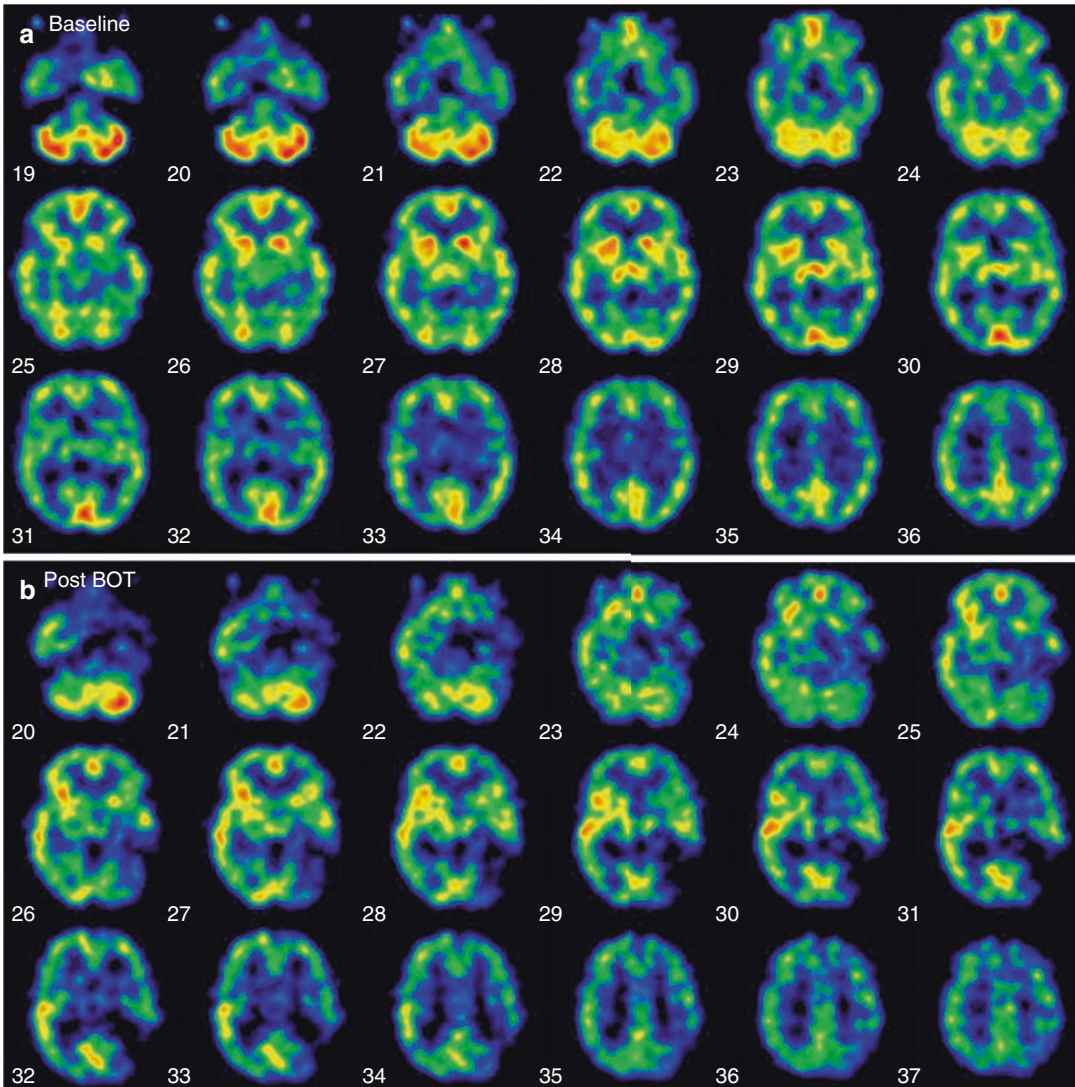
(a) Pre-balloon occlusion baseline study: patient is a 55-year-old female with a skull base meningioma. The patient was injected with radiopharmaceutical (44.5 mCi of ^{99m}Tc -HMPAO IV) in a dimly lit and quiet room during the resting state. After waiting approximately 10 min for radiotracer incorporation into the brain, a brain SPECT scan was performed. SPECT images demonstrate symmetric tracer uptake in both the left and right internal carotid artery territories. This baseline study shows good filling of all vascular territories. Findings were consistent with normal baseline resting-state study, with no major vascular territorial significant reductions of blood flow. Post balloon occlusion images (b). In angiography suite, balloon test occlusion (BOT) of the left internal carotid artery was performed. During the 13 min of balloon inflation, the radiotracer (30.4 mCi of Tc-99m Ceretec) was
